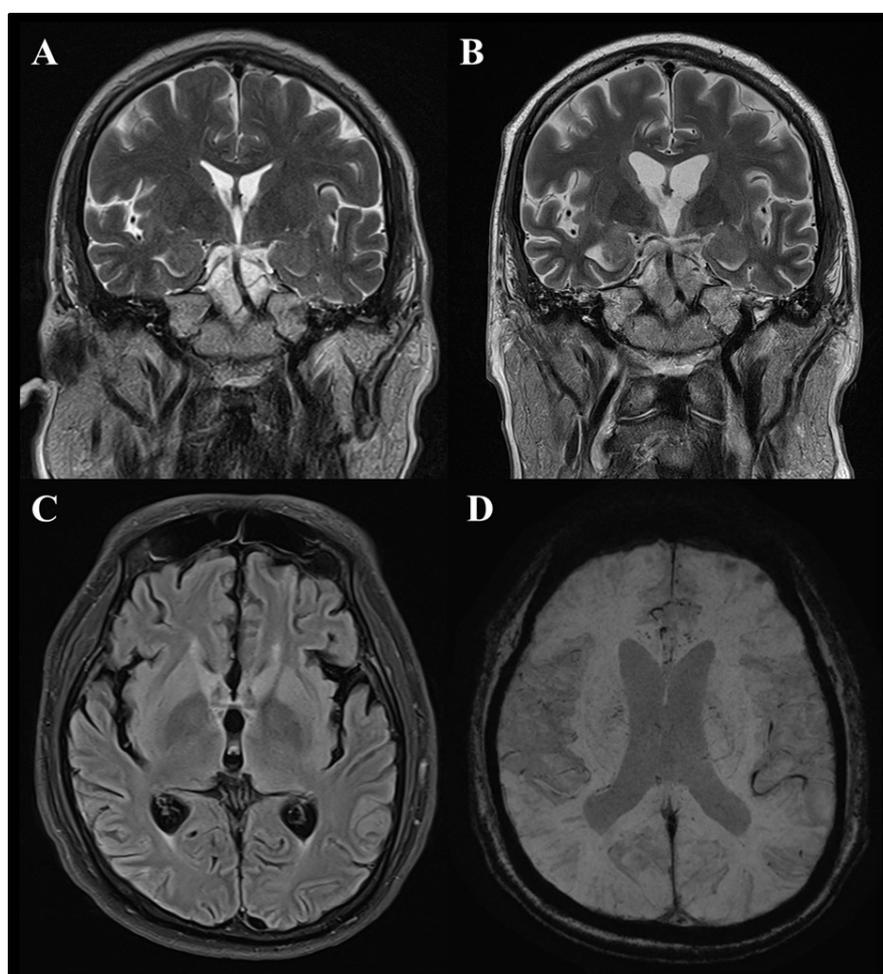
Magnetic resonance imaging (MRI) brain images from the patient.
